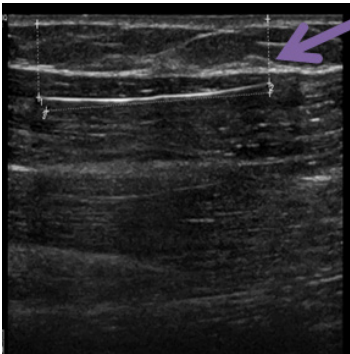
Locating the etonogestrel implant in the left arm by ultrasound
